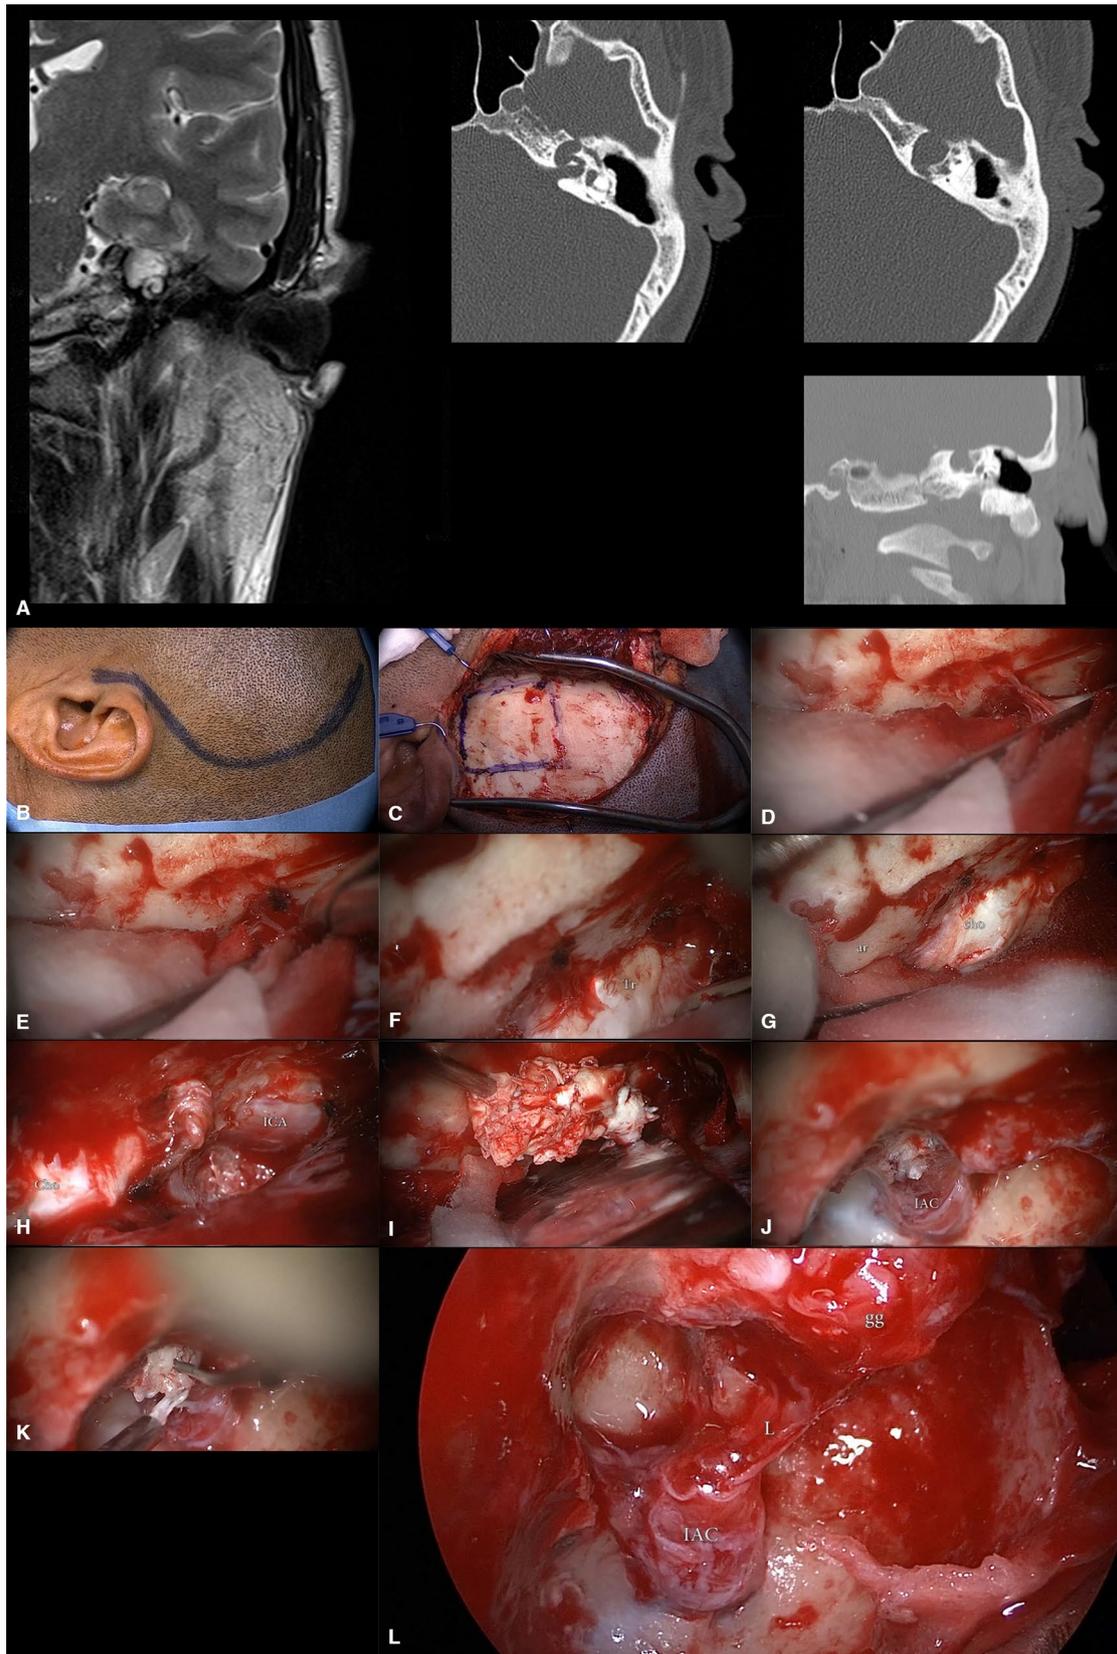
Middle cranial fossa approach. Left ear. a Preoperative CT scan (upper left and lower left) and MRI (right) showing the cholesteatoma involving the floor of the middle cranial fossa as far as the internal auditory canal (IAC). b Incision in the shape of a question mark; c quadrangular craniotomy; d middle meningeal artery; e great petrosal nerve (the middle meningeal artery appears coagulated and transected superiorly); f *Tr* trigeminal nerve; g *ar* arcuate eminence, *cho* cholesteatoma; h *ICA* internal carotid artery, *cho* cholesteatoma; i removal of the first portion of cholesteatoma; j the residual cholesteatoma involving the internal auditory canal (IAC); k removal of the pathology; l endoscopic check of the surgical field. *L* labyrinthine segment, *IAC* internal auditory canal, *gg* geniculate ganglion
